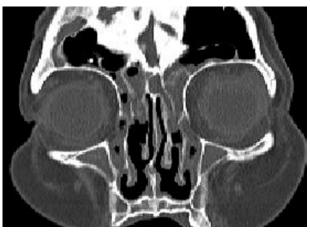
Coronal CT image shows pansinusitis, scleral thickening and suspected left lateral retinal detachment.
